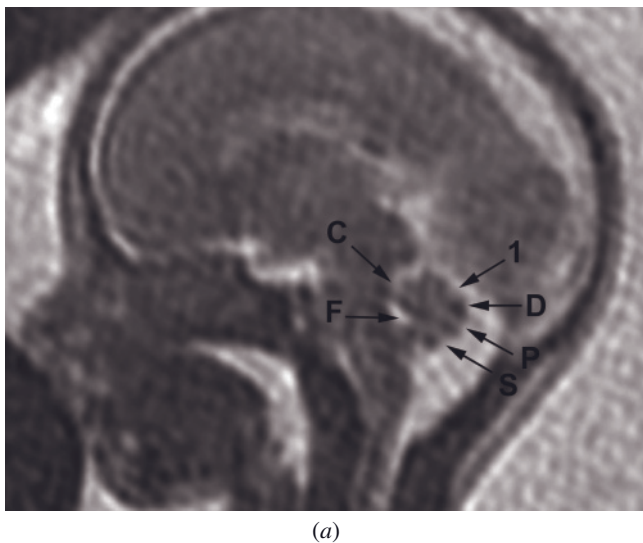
Normal cerebellar vermis. Sagittal T2-weighted SS-ETSE image of the cerebellar vermis (a) with magnified view for detail (b). Note the fastigial point (F), primary fissure (1), prepyramidal fissure (P), preculminate fissure (C), and secondary fissure (S) in this 19-week fetus.
